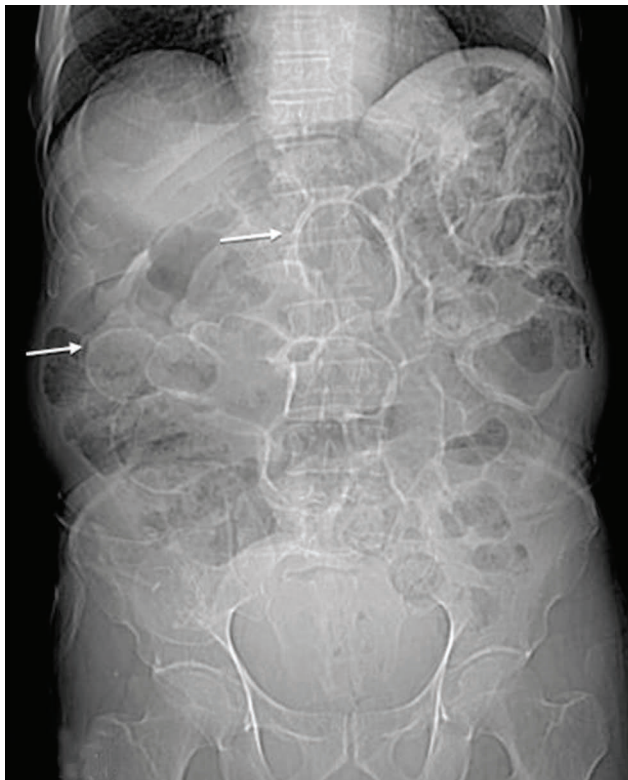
X-ray abdomen-supine AP view showing dilated bowel loops (which later proved to be diverticula) with bowel wall clearly seen (arrows) due to intraluminal and extra luminal air (Rigler's sign positive). AP, anteroposterior.
